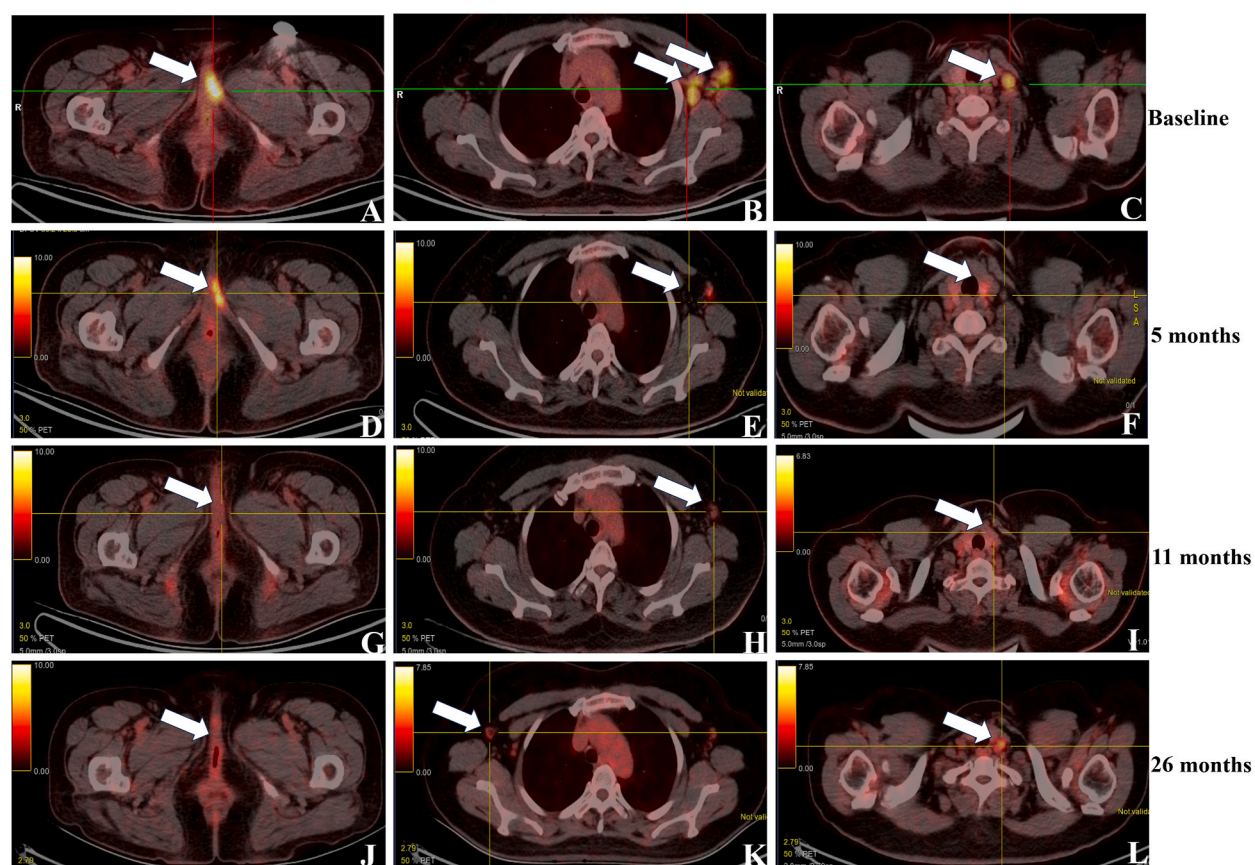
Representative images of a patient with TMB-H who had a PFSi as long as 26 months. This patient was diagnosed with HGNECC (FIGO stage IIB) in March 2018 and treated with radiotherapy plus chemotherapy (completed in September 2018). During the regular follow-up (July 2019), PET-CT indicated a widespread metastasis in the left vulva (A), left axillary lymph nodes (B), and left supraclavicular lymph nodes (C). This diagnosis was confirmed by pathology via biopsy, and the patient was treated with chemotherapy plus a PD-1/PD-L1 inhibitor (completed in November 2019). Subsequently, PET-CT was performed again to evaluate the efficacy. As shown in (D–F), a notable shrinkage was observed in all the three metastasis sites. Approximately 0.5 year later (April 2020), PET-CT indicated minimal metabolic activities in these sites (G–I). Ten months later (September 2021), the right axillary lymph nodes (K) and left supraclavicular lymph nodes (L) showed disease progression, while no change was noted in the left vulva (J). *: the metastasis sites are indicated by white arrows.
